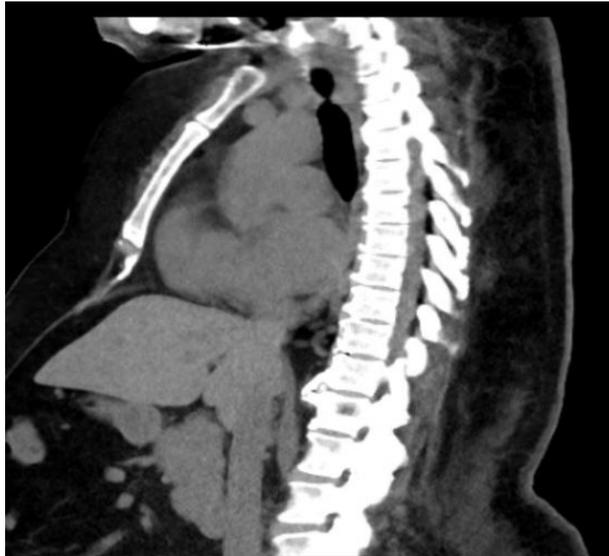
Sagittal CT scan of the chest showing cardiomegaly and a narrowed tracheal caliber.
